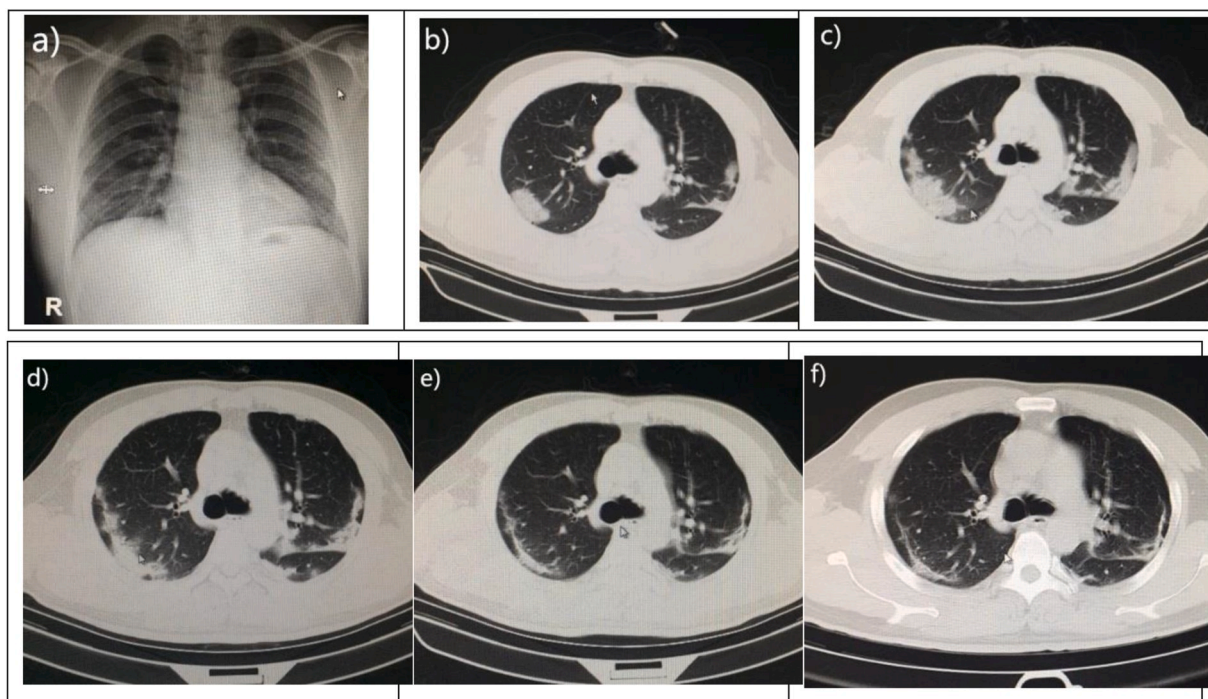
a) Posteroanterior Chest Radiographs, January 25, 2020. b–f: Computerized Tomography. b) January 28, 2020; c) January 31, 2020; d) February 04, 2020; e) February 06, 2020; f) February 14, 2020.
